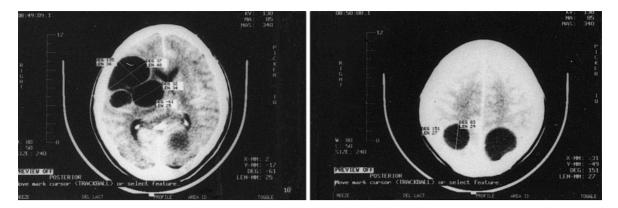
CT scan demonstrating multiple hydatid cysts before operation
